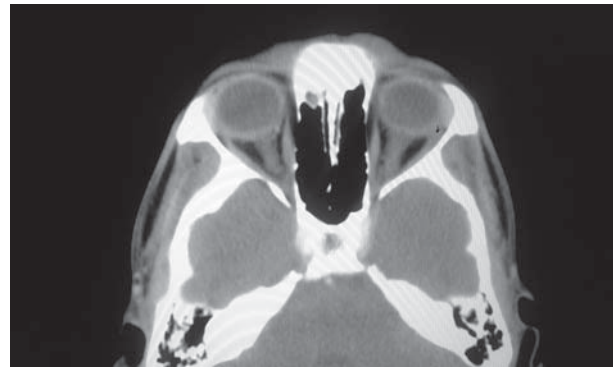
Contrast enhanced CT scan of orbit shows a rim enhancing cystic lesion with central scolex involving the right lateral rectus muscle (arrow).
